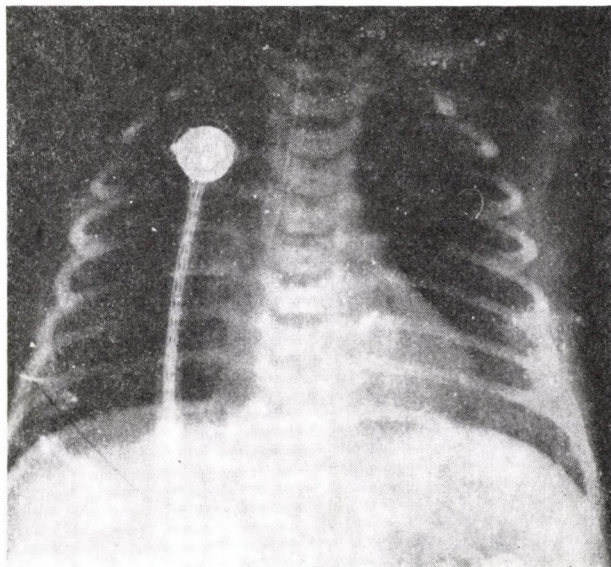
Case 2. Chest X-rays at 17.5 hours after the beginning of HFOV. Pneumomediastinum and pulmonary oedema disappeared, the lungs are radiolucent
